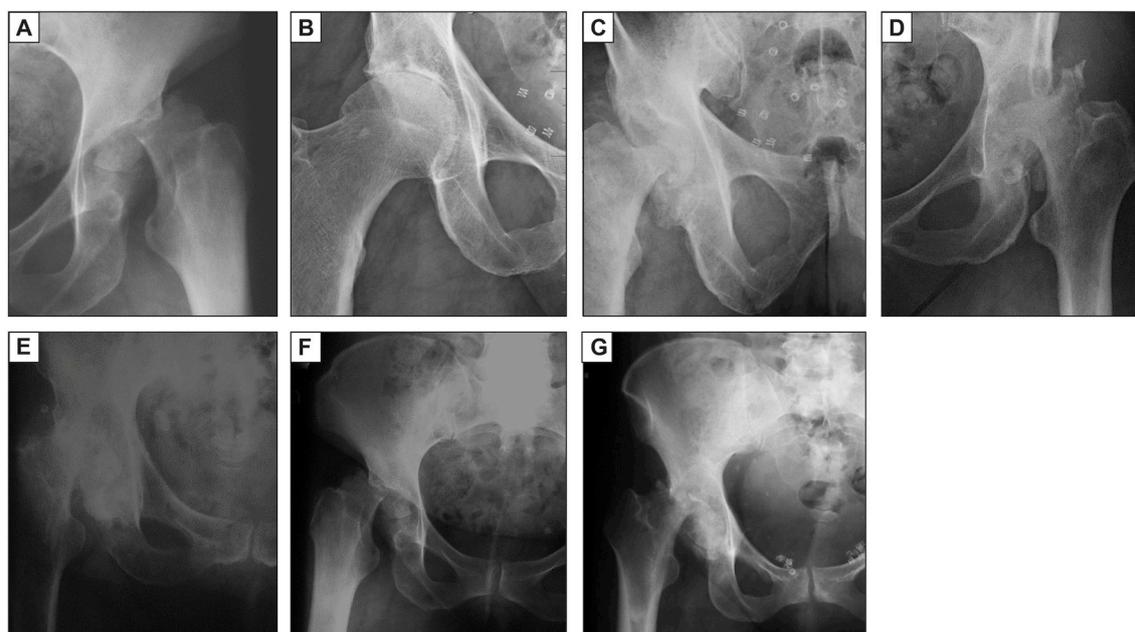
Radiographic appearance and interval progression of RPOA. 66 year-old with a history of right hip pain. (A,B) Initial radiograph. Right hip joint with slight joint narrowing. (C,D) One month later. End-stage osteoarthritis of the right hip joint in the same patient as A. Severe destructive changes to both the acetabulum and femoral head can be seen.
